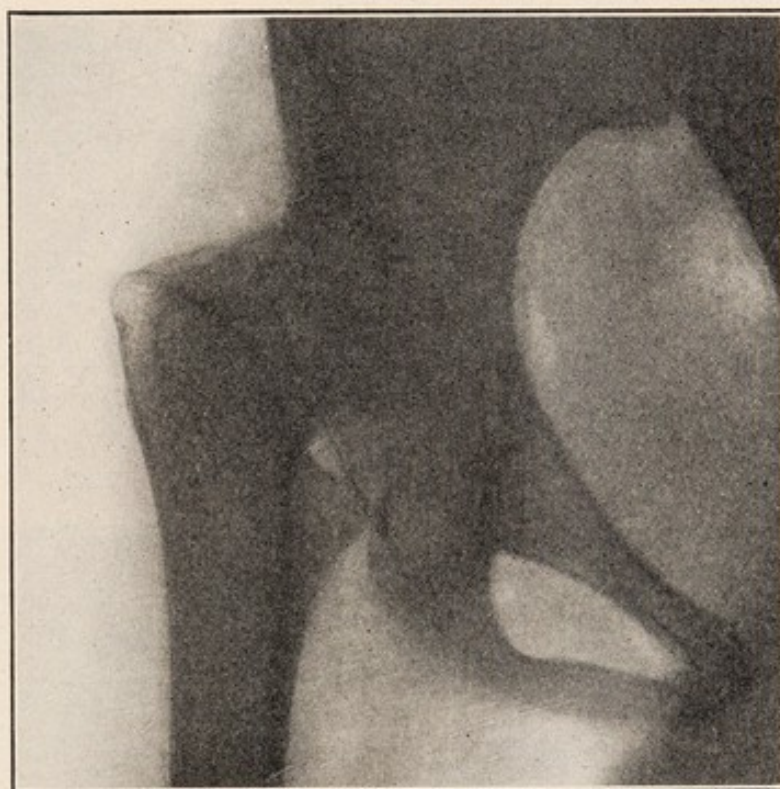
X-ray of ankylosed tuberculous hip before Operation VI.
